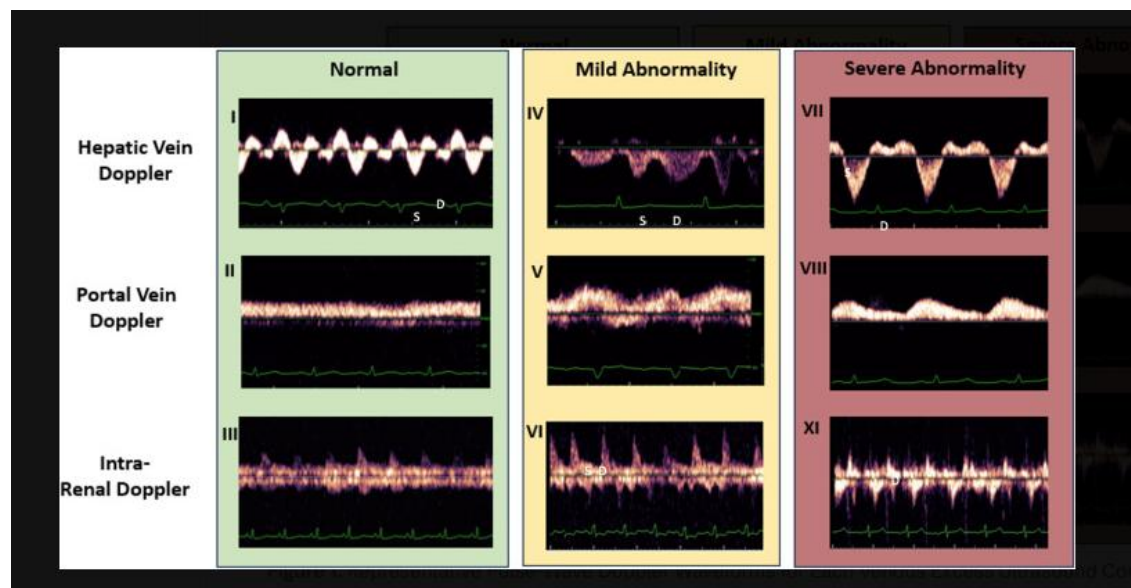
Doppler waveforms for each of the three venous beds. From JACC Adv, January 2026.
